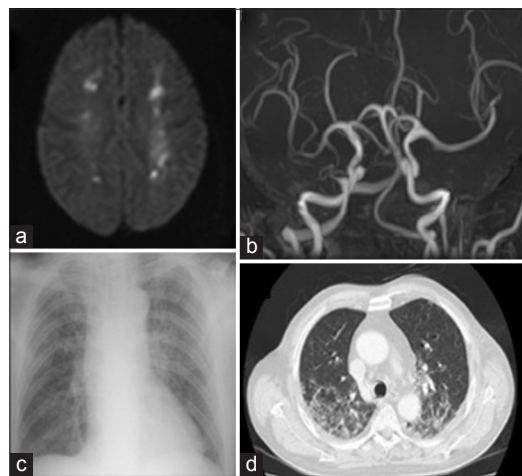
Magnetic resonance imaging of the brain performed on the second presentation showing diffuse bilateral asymmetrical predominantly subcortical hyperintense white matter lesions on diffusion-weighted imaging (a). Cranial magnetic resonance angiography demonstrated no abnormalities (b). XP (c) and computed tomography (d) of the chest showed patchy areas of ground-glass opacity in both lungs
